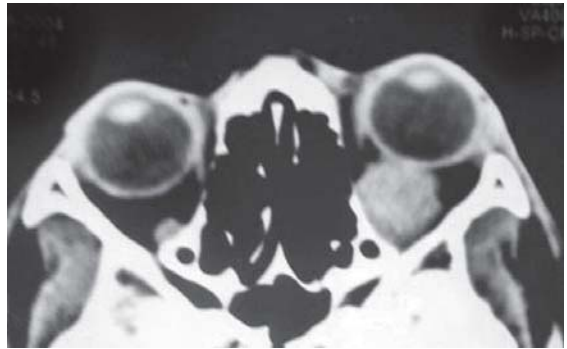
CT scan of orbit showing spindle-shaped dilatation of optic nerve (Courtesy: Dr MS Bajaj, Dr RP Centre, New Delhi)
